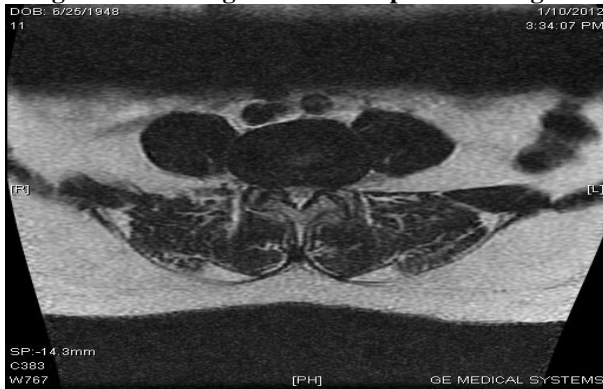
Lumbar spondylosis with multilevel degenerative disc disease leading to nerve roots impingement and spinal canal stenosis in a 63 year old female referred for lumbar MRI
